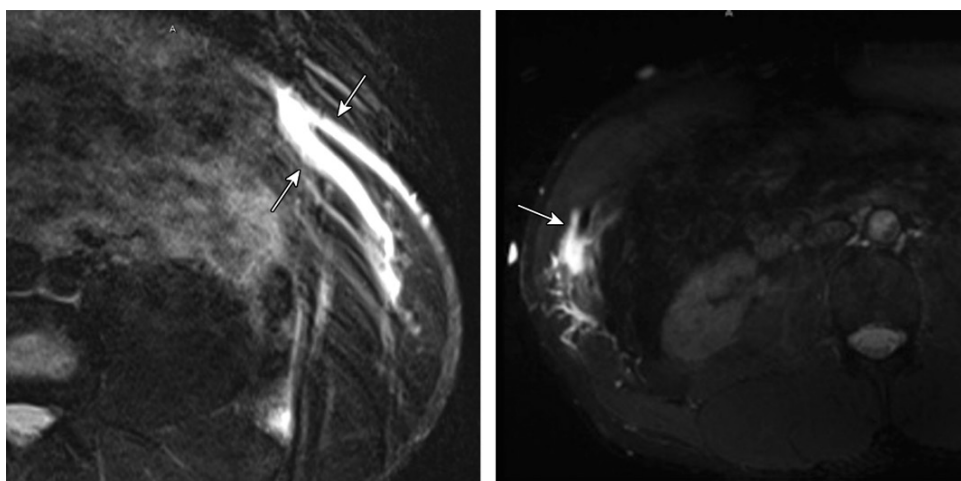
Magnetic resonance (MR) images of two different athletes who presented with abdominal pain. (a) Axial fluid-sensitive MR image shows an external oblique strain and tear (arrows) in a 23-year-old man. (b) Axial fluid-sensitive MR image shows an internal oblique strain and tear (arrow) in a 29-year-old man.
